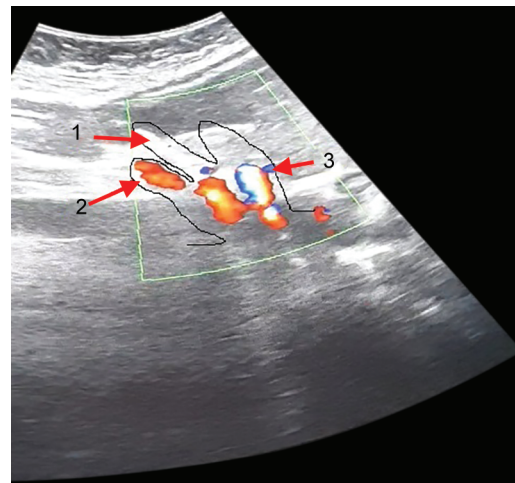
Under ultrasonography “Trident sign of Lord Shiva” in ultrasonography (long axis in-plane) formed by three components superior mesenteric artery (2), celiac trunk (3) and block needle (1) placed between these two vessels
